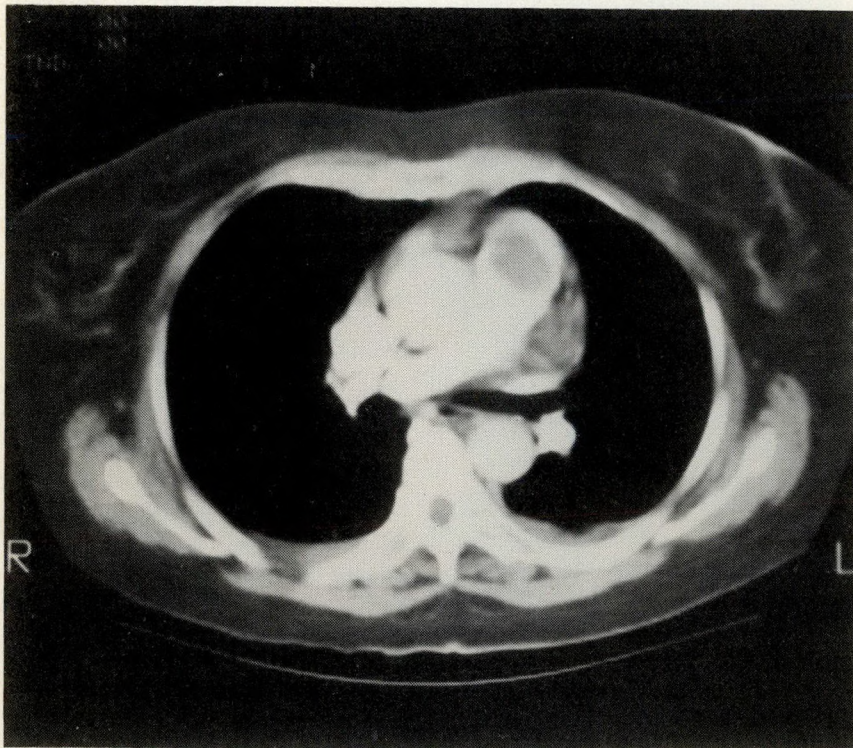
Contrast computed tomogram of thorax demonstrates filling defect in pulmonary artery.
